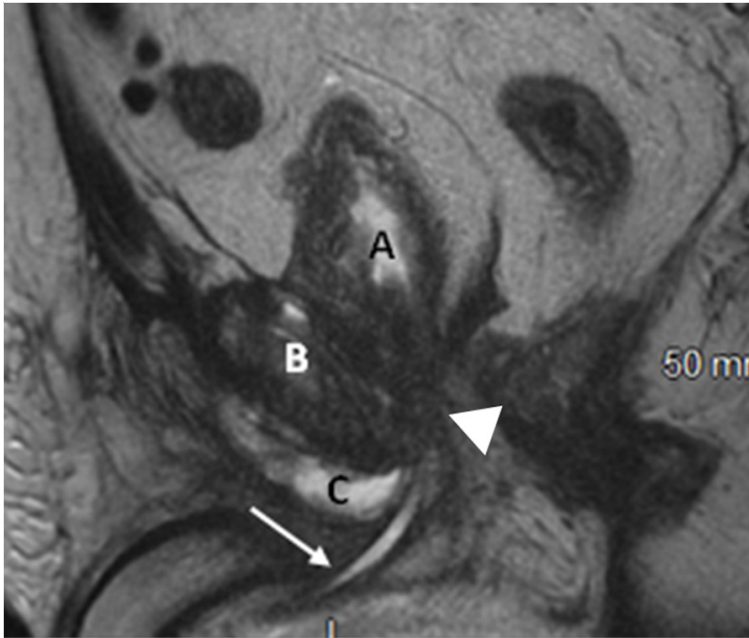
Sagittal T2-weighted MR image through the pelvis demonstrating the bladder (A), pubic bone (B), bulbomembranous urethra (arrowhead), and fistula with fluid collection (C) extending from the posterior urethra to the pubic bone. Note the anterior urethra (arrow).
